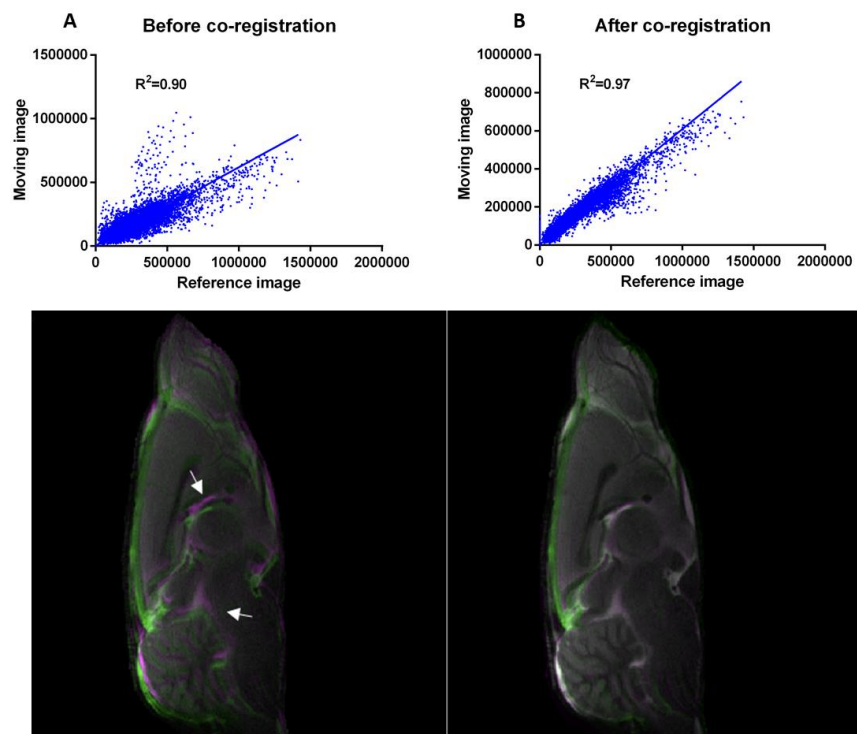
Visual assessment before and after T_2 weighted MR image co-registration. (A) 2D histogram of two overlapping images before co-registration. (B) 2D histogram of two overlapping images after co-registration using rigid transformation. In the overlapping images, grey areas correspond to areas that have similar intensities, while magenta and green areas show places where one image is brighter than the other. There is a noticeable improvement in the alignment of the images (before co-registration, $R^2=0.90$; after co-registration, $R^2=0.97$).
